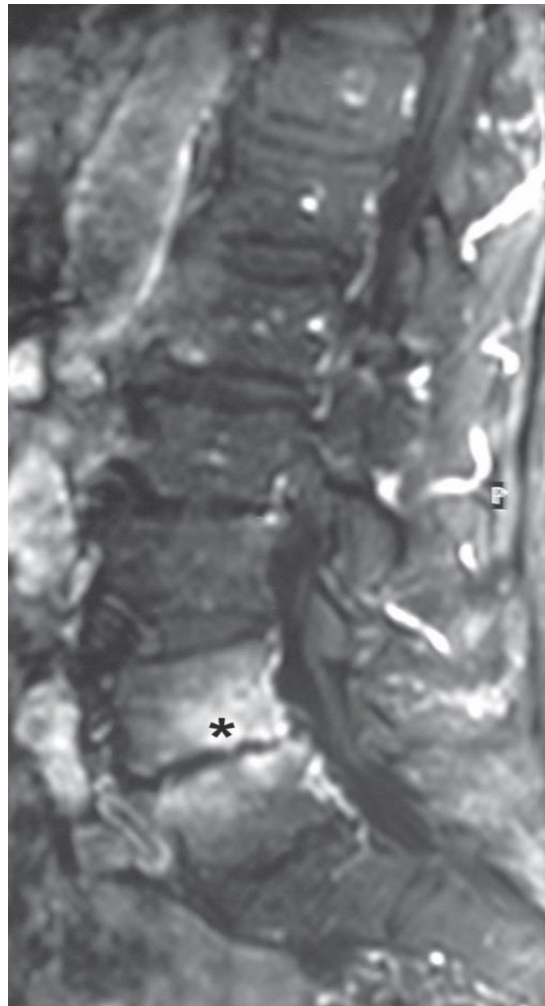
Sagittal lumbar spine MRI T1 image without gadolinium showing bony hyperintensity in keeping with osteomyelitis (black *)
